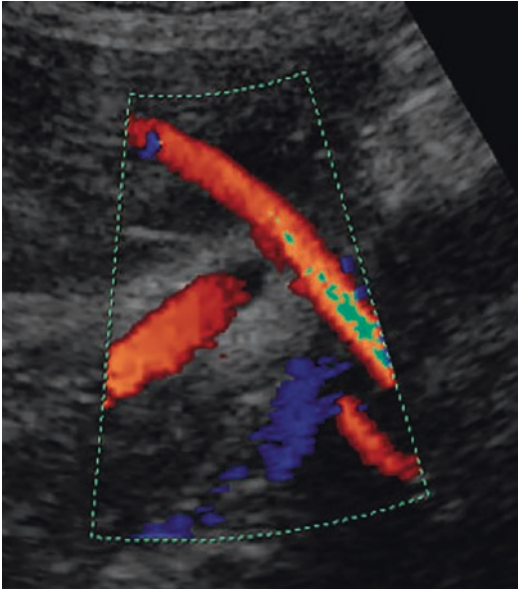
Color Doppler image of the uterine artery at the level at which it crosses the external iliac artery [19]
